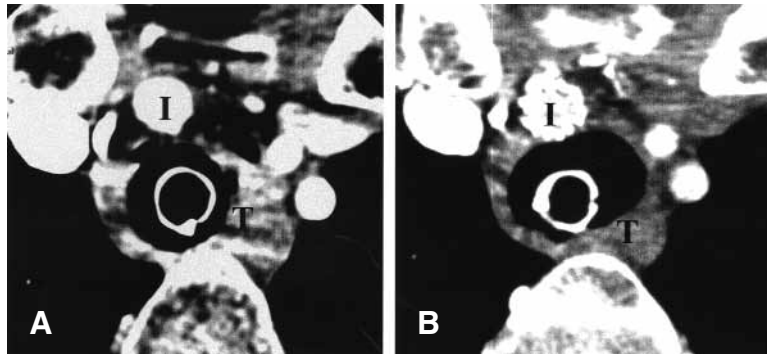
A, Computed tomogram on admission demonstrating markedly diseased trachea associated with hematoma in mediastinum. Note that trachea is closely adjacent to innominate artery, with severe paratracheal inflammation. B, Computed tomogram 10 months after procedure demonstrating improvement of paratracheal inflammatory changes, including disappearance of hematoma, without mediastinitis. *T*, Trachea; *I*, innominate artery.
